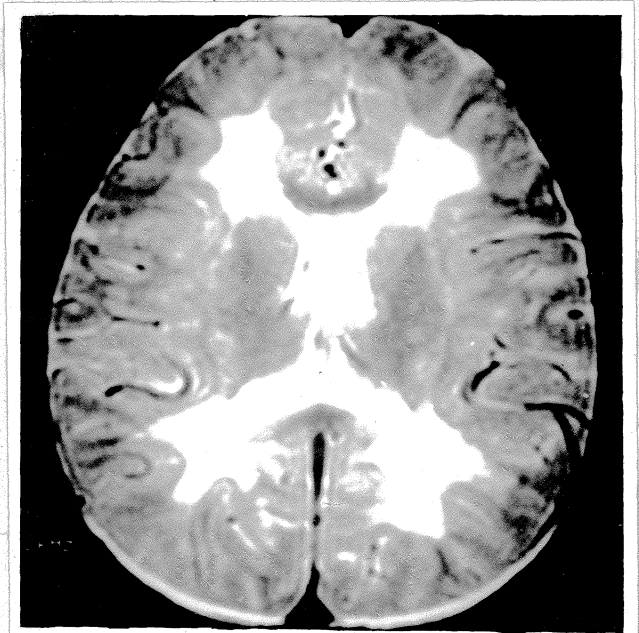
Diffuse subcortical white matter dysmyelination in a case of MLD.(MRI T₂WI)
